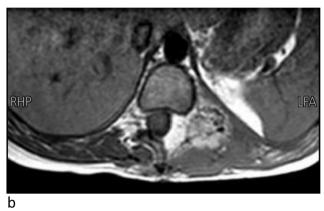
a: T2 sagittal view MRI for the dorso-lumbar spinal area showing complete resection of the tumor at level D12-L1 with decompression of the cord.
